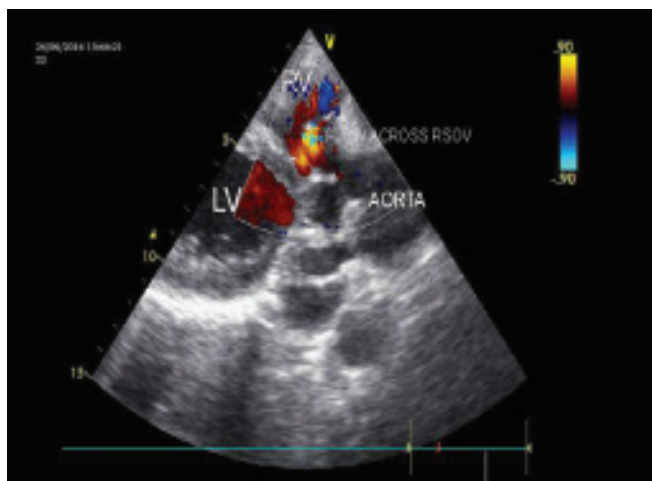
Parasternal long axis view – showing flow across RSOV in to RV
